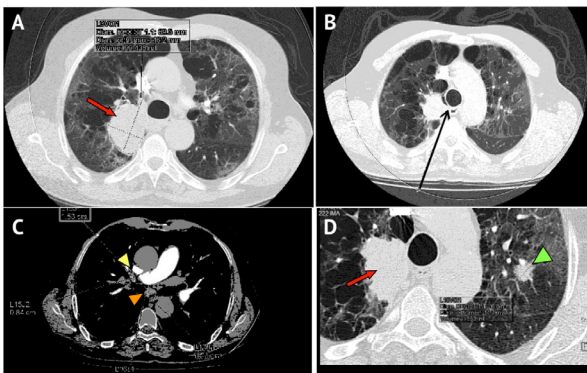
A: Representative axial images showing a tumor process of the right upper lobe (arrow) that occupies the posterior segment and leans against the mediastinal pleura. The mass measured 46.2×56 mm in the axial plane, B: and was in close contact with the esophagus (arrow), C: CT imaging also showed that the process was associated with an ipsilateral subcarinal hilar node measuring up to 0.82×15.3 mm (yellow arrowhead) and another in the aortopulmonary window measuring 1.68×17.8 mm (orange arrowhead), D: Another suspicious pulmonary nodule was discovered in the left upper lobe measuring 14.7×16.8 mm.
